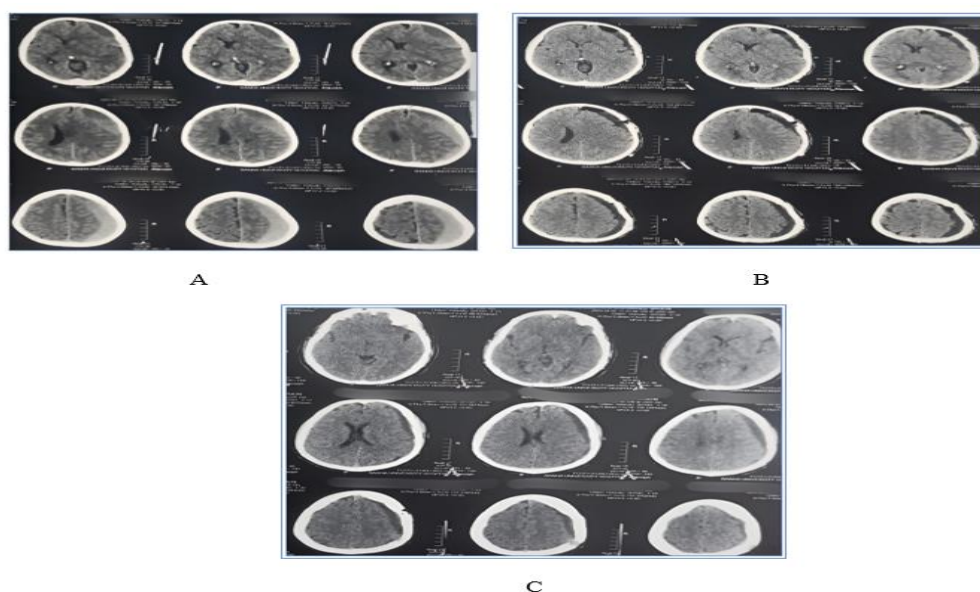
(A) Preoperative CT brain axial view showing LT parietal sub-acute SDH; (B) Immediately Post-operative CT Brain Axial view showing evacuated hematoma, (C) CT Brain axial view FU after 1 month of surgery showing LT recurrent parietal SDH.
